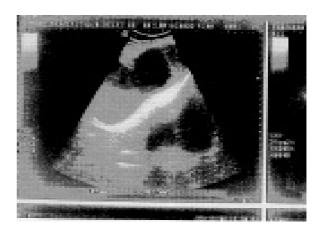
Ultrasound showing an eliptical mass 16.7 x 8.6 cm adjacent to left ovary with cystic and solid component suggestive of a ovarian mass or a cystic degenerated fibroid.
